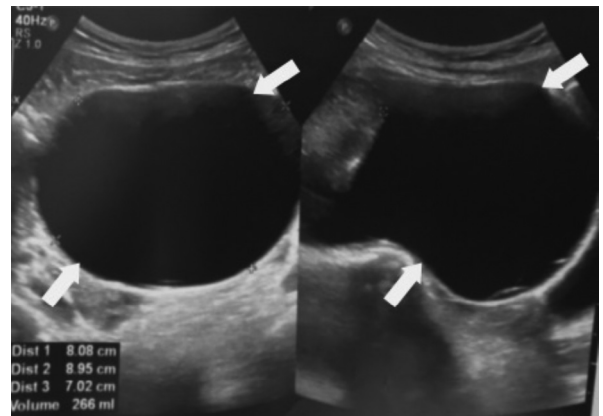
Abdominal ultrasound image – a circular lesion adjacent to the left ovary
